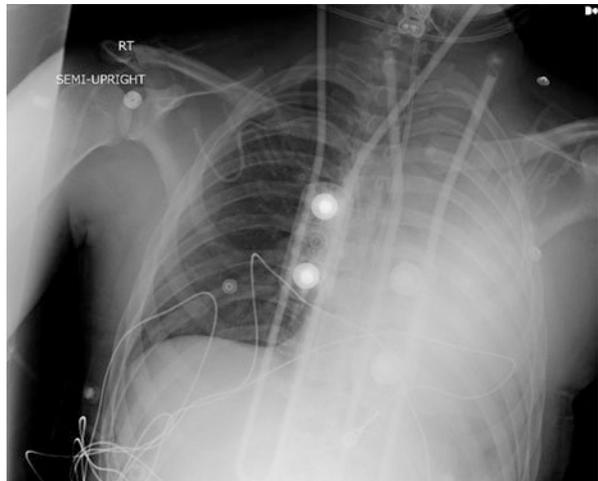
Chest x-ray (AP view)
